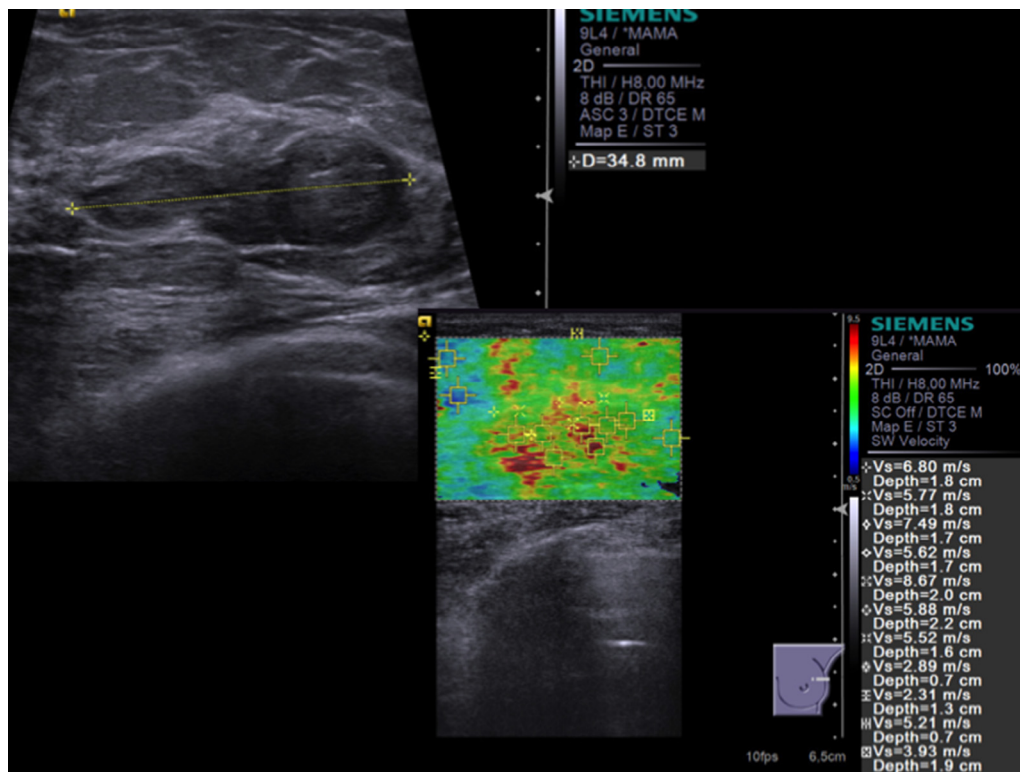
Example of a lobulated hypoechoic lesion in B-mode ultrasonography image (left). The color elastogram and the respective measurements of shear wave velocity (right) revealed elevated velocities. The final diagnosis was fibroadenoma—with abundant collagen matrix.
